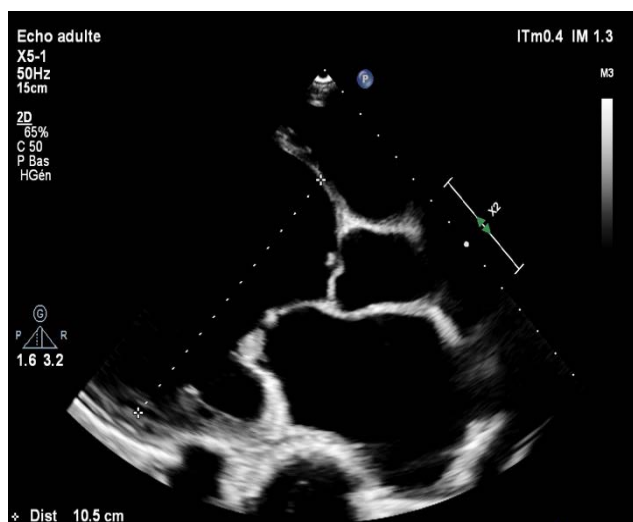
Parasternal long-axis view of end-stage left-ventricular remodeling: Parasternal long-axis view showing extreme left-ventricular dilatation (end-diastolic diameter 105 mm, indexed LVEDD 68 mm/m²) with marked wall thinning, consistent with terminal ventricular remodeling secondary to long-standing untreated degenerative mitral regurgitation
